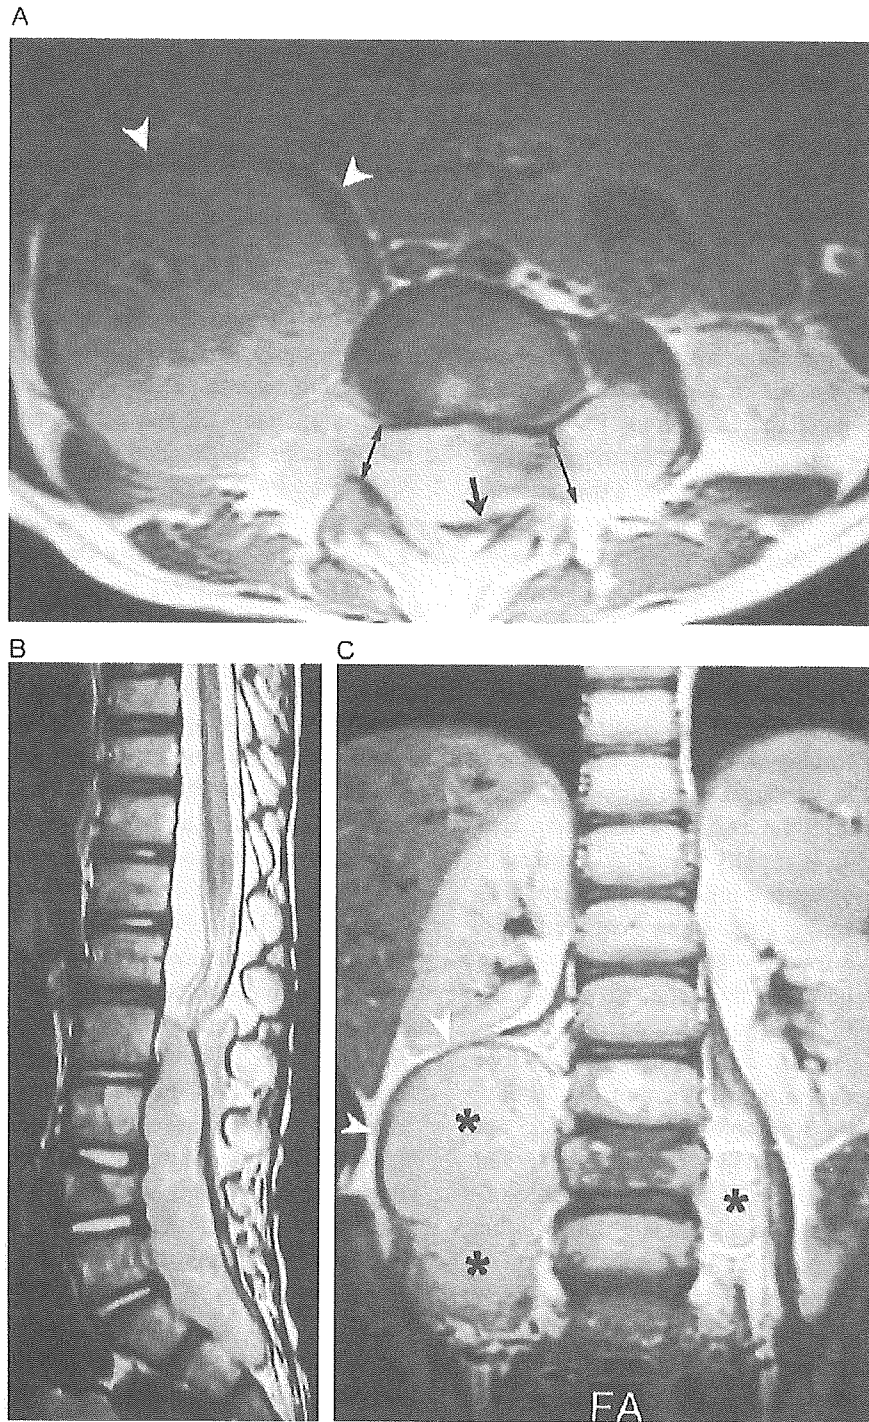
Retroperitoneal neuroblastoma with bilateral intraspinal extension in a 3-year-old boy. (A) Gd-enhanced coronal T1-weighted image. (B) Sagittal T2-weighted image. (C) Gd-enhanced axial T1-weighted image. Coronal image shows large tumour masses to both sides of the lumbar spine (asterisks, A) and a pathologic L4 vertebral body. The size of the intraspinal extradural component is huge (B). Axial image shows bilateral dumbbell extension through widened neural foramina (double arrows, C) and marked compression of the thecal sac (single arrow, C). Notice marked elevation and displacement of the right psoas muscle (arrowheads, A,C).
